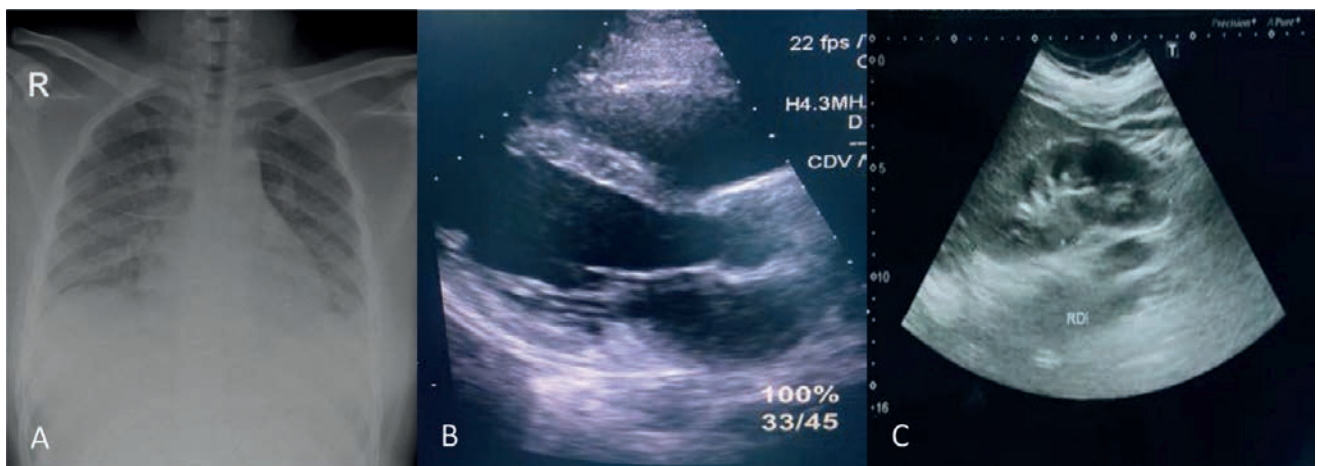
A) Chest X-ray: blunting of the left costophrenic angle, B) cardiac ultrasound: dilated left atrium and ventricle, normal systolic function, LVEF = 60%, a small circumferential pericardial effusion and bilateral pleural fluid, C) abdominal ultrasound: 15 mm of fluid in the pouch of Douglas, small bilateral pleural effusion
